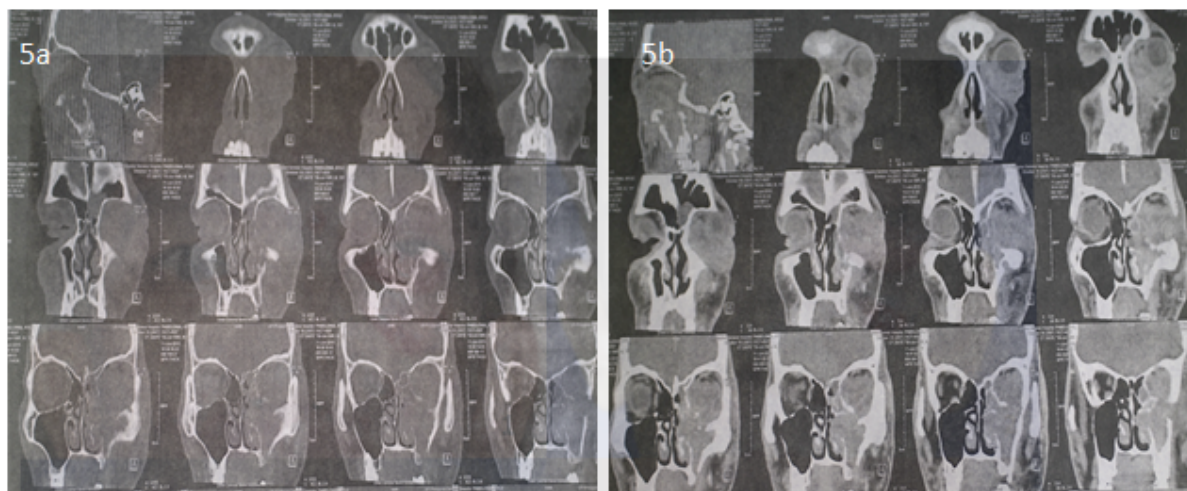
(a) Facial CT scan with Orbital cuts, Coronal View, Bone window showing lysis of bone and tissue invading the maxillary and nasal sinus with extension to the left orbit (b) Facial CT scan with Orbital cuts, Coronal View, showing lysis of bone and tissue invading the maxillary and nasal sinus with extension to the left orbit.
